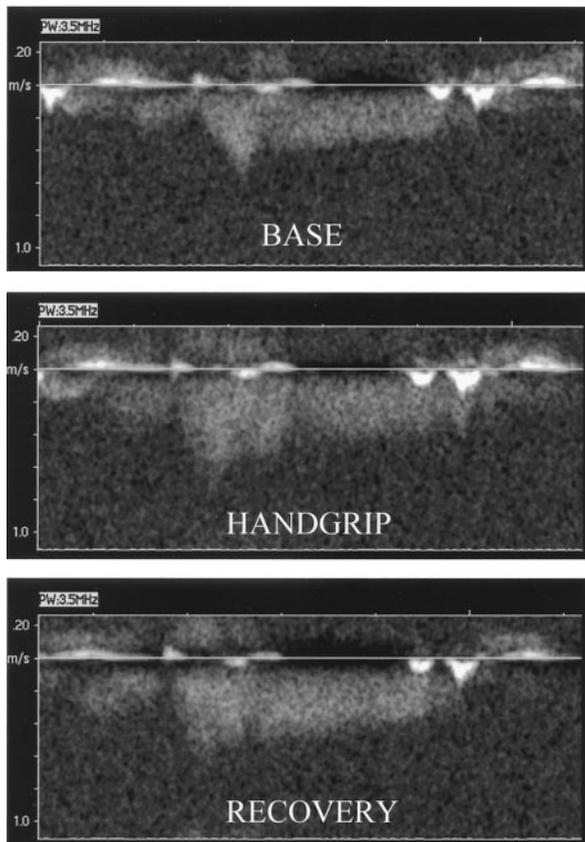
Coronary Doppler tracing during 30-s handgrip in a subject with normal coronary arteries. The Doppler intensity and flow velocities remain unchanged throughout the test.
